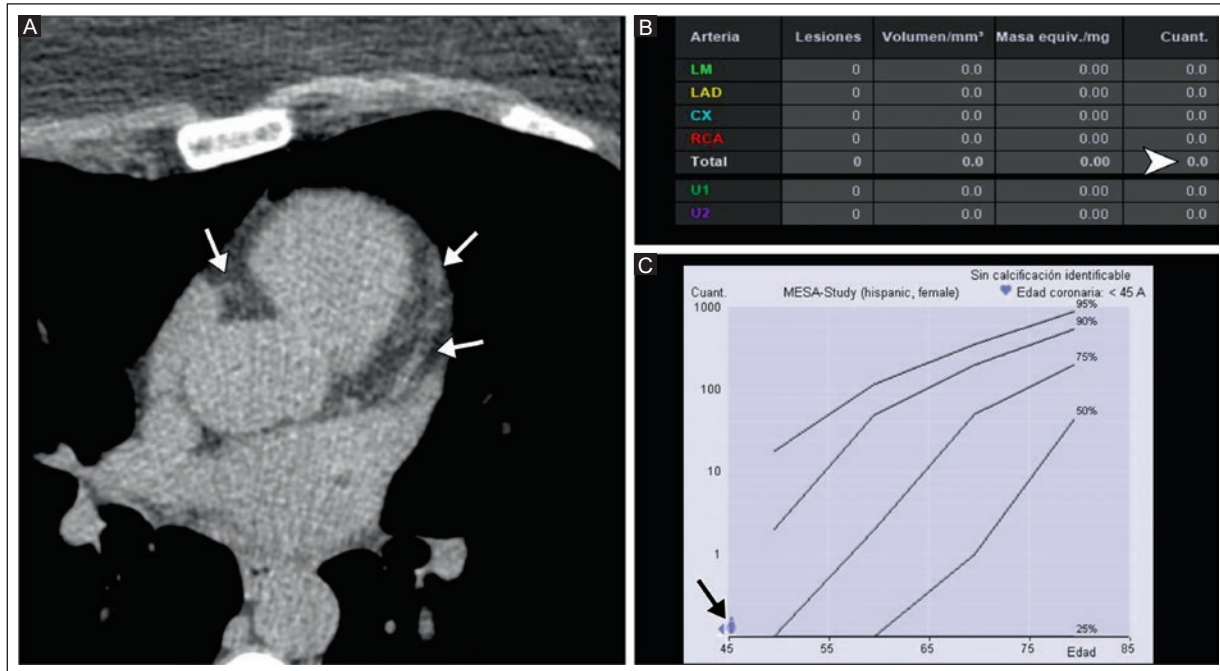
A 42-year-old asymptomatic woman. A: axial view of the coronary CT calcium score without CAC (arrows). B: table of CAC volume and mass values determined according to AS (arrowhead). C: percentile chart with AS by ethnicity and age, with percentiles between 75 and 90% (black arrow) based on MESA.
